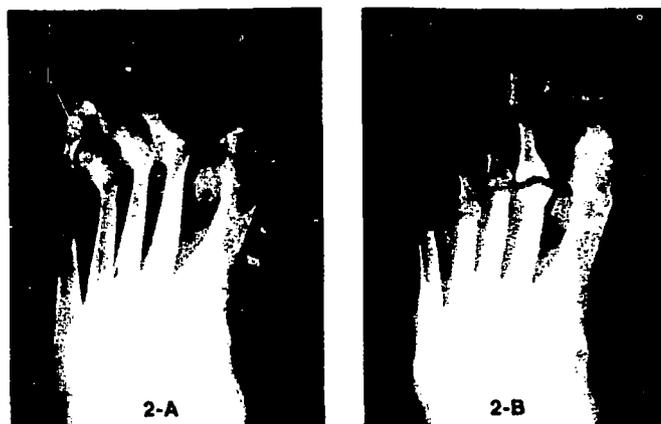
Pre-operative roentgenogram shows rheumatoid arthritic foot with painful pseudoarthrosis following resection arthroplasty of great toe and dislocation of MP joints in 2, 3, 4, 5 toes.
